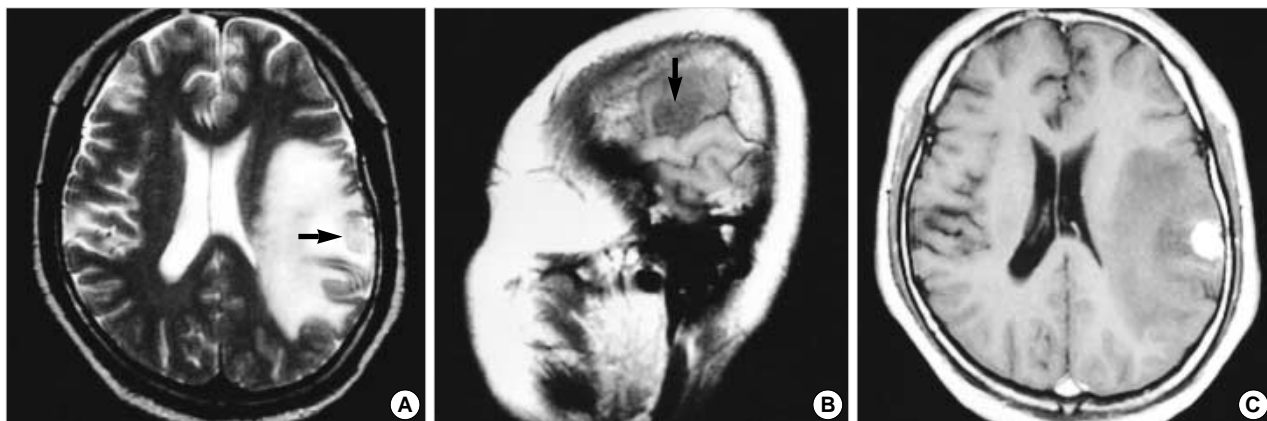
(A) Axial T2-weighted magnetic resonance (MR) image showing slightly high signal intensity mass with severe surrounding edema in the left parietal cortex (arrow). (B) Sagittal T1-weighted MR image revealing an ill-defined low signal intensity mass (arrow). (C) Strong homogeneous enhancement of the mass as seen on the axial post-contrast T1-weighted MR image. The mass is located just beneath the dura, however, there was no connection to the dura.
